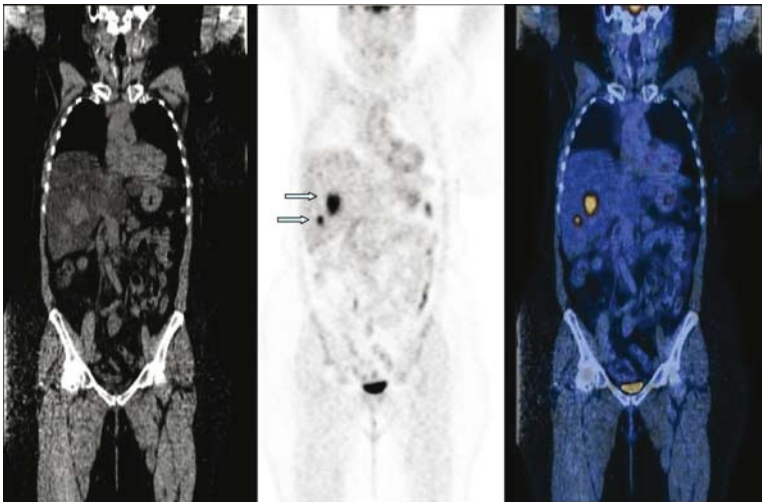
A 60-year-old patient, 3 years after right mastectomy and adjuvant chemo- and radiotherapy, on continued hormonal therapy due to invasive duct breast cancer. Referred with elevated serum Ca 15.3 and a small liver lesion on CT. CT (left), PET (middle) and PET/CT (right) coronal images FDG avid liver lesions in the right lobe of the liver (arrows). The patient received chemotherapy and after improvement underwent partial hepatectomy. 16 months later the patient was diagnosed with disease progression, with new FDG avid lesions in left lobe (not shown)
